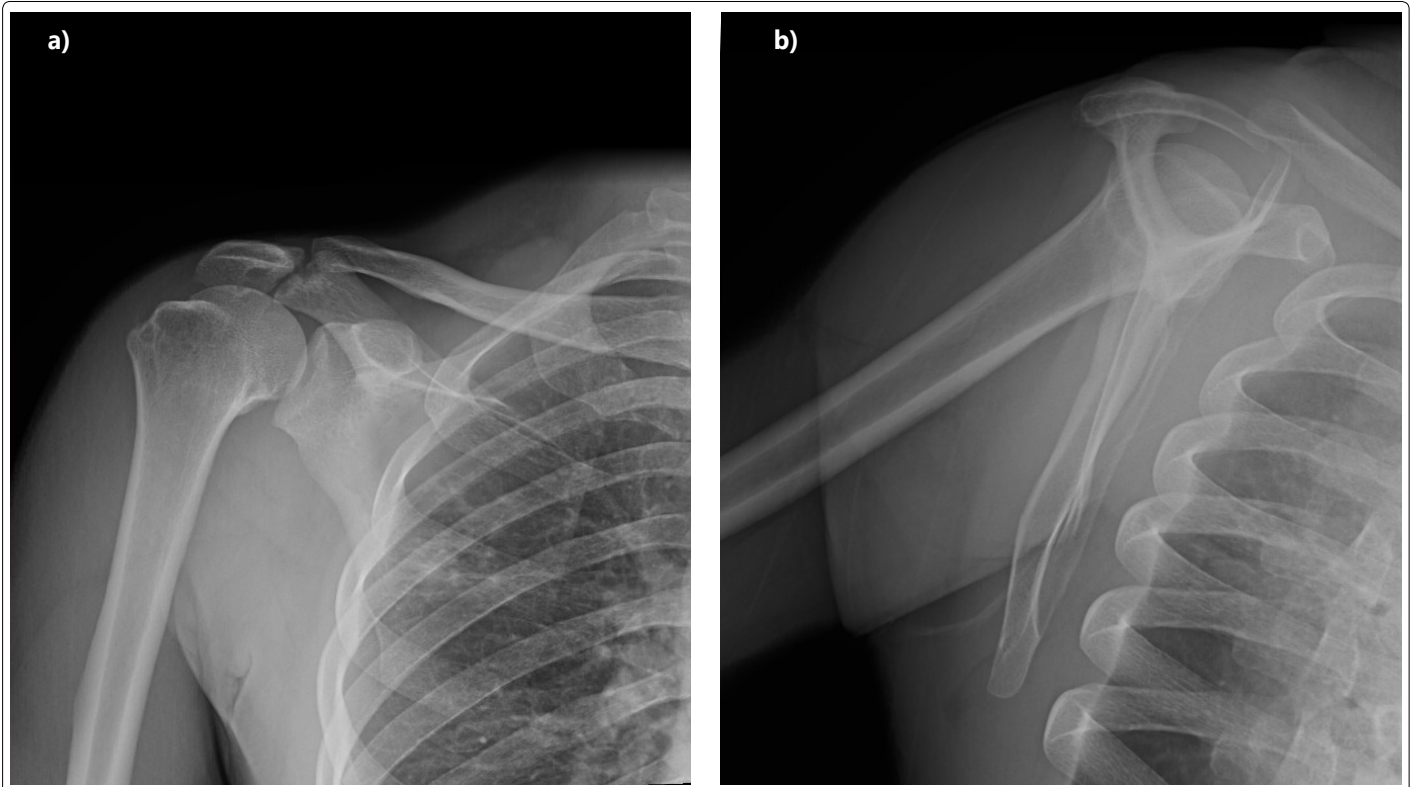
(a,b): Shoulder X-ray showing non-union of the acromion with irregularity between fragments
